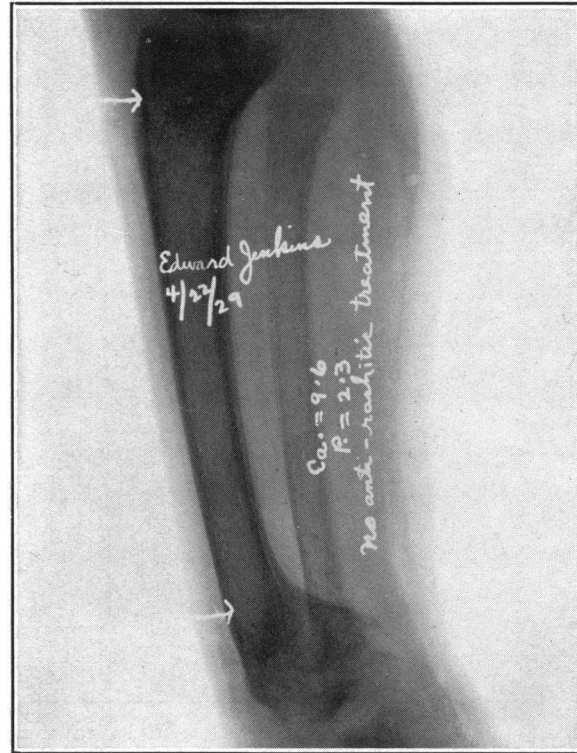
E. J., aged 3 years. The same child as in Fig. 6. X-ray photograph of leg showing origin of the sabre-shin deformity. The lower epiphysis of the tibia has been displaced backwards on the diaphysis. The deformity is situated just above the ankle.
